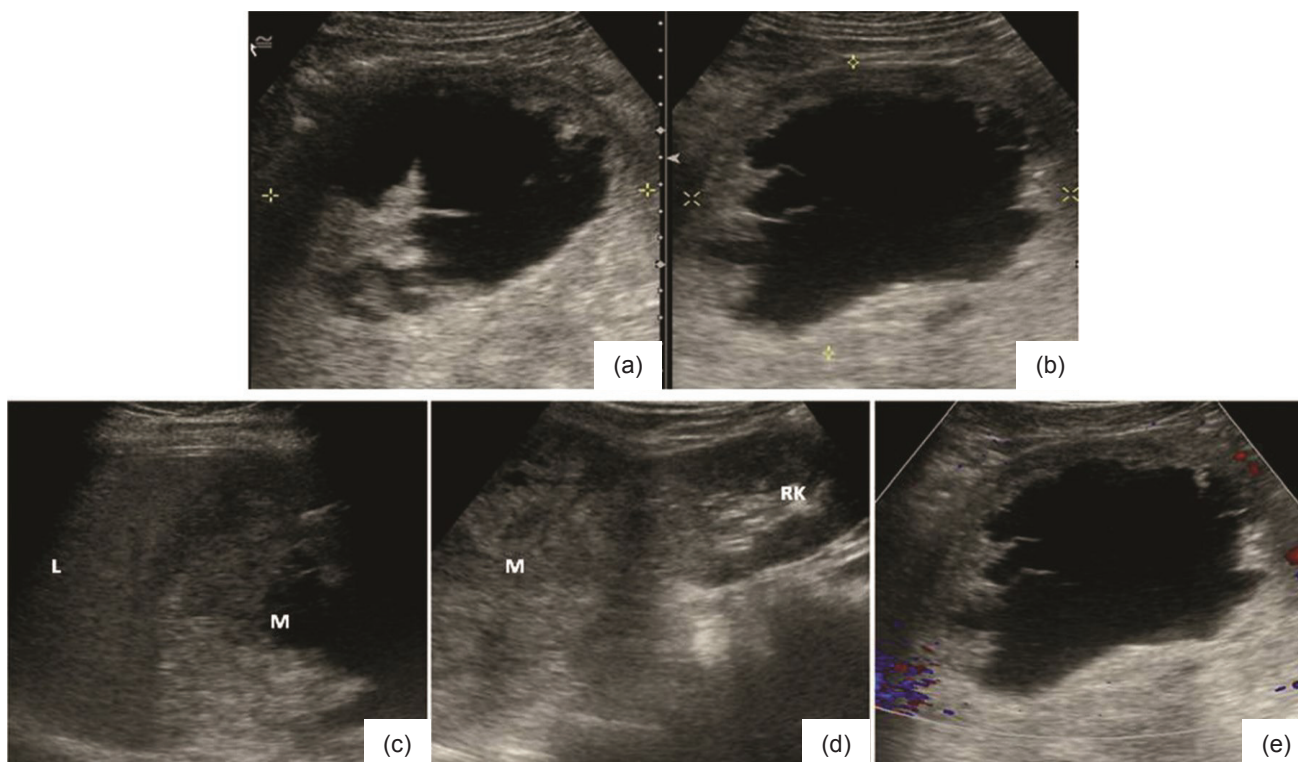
a and b. Transverse and sagittal sonographic images revealing a complex mass at the region of the porta hepatis; c and d. Sagittal images showing superior displacement of the right hepatic lobe (L) and inferior displacement of the right kidney (RK) by the mass (M); e. Minimal peripheral enhancement detected under color Doppler imaging.
